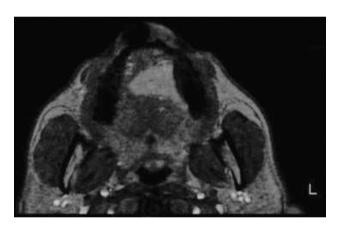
Gadolinium-enhanced, T1-weighted MRI showing an enhancing mass at the left side of the tongue.
